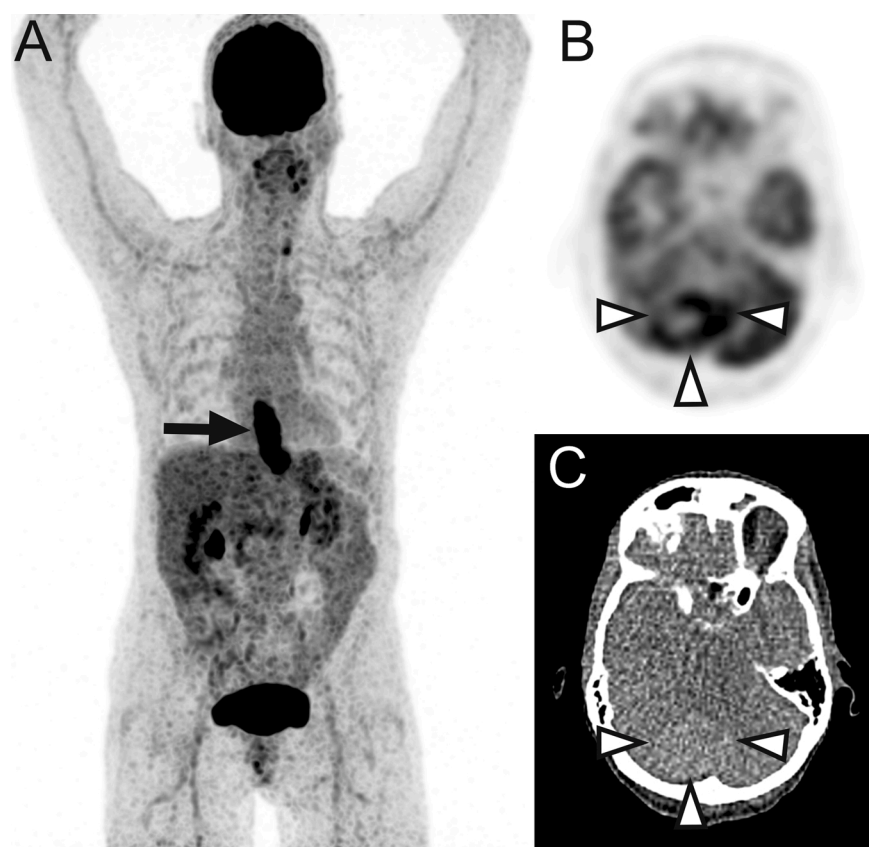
A 62-year-old woman who had undergone neoadjuvant chemoradiation therapy for esophageal cancer. Low-dose FDG-PET/CT was performed for restaging purposes. Coronal maximum intensity projection FDG-PET (A), axial FDG-PET (B), and axial low-dose CT (C) are demonstrated. FDG-PET showed high FDG uptake at the location of the primary tumor (A, arrow) that had decreased compared to baseline FDG-PET (not shown). Although a mass with peripheral high FDG uptake was present in the right cerebellar hemisphere (B and C, arrowheads), this was not described in the original report. Follow-up confirmed metastatic disease. This perceptual error was corrected with an addendum 7 days after authorization of the original report.
